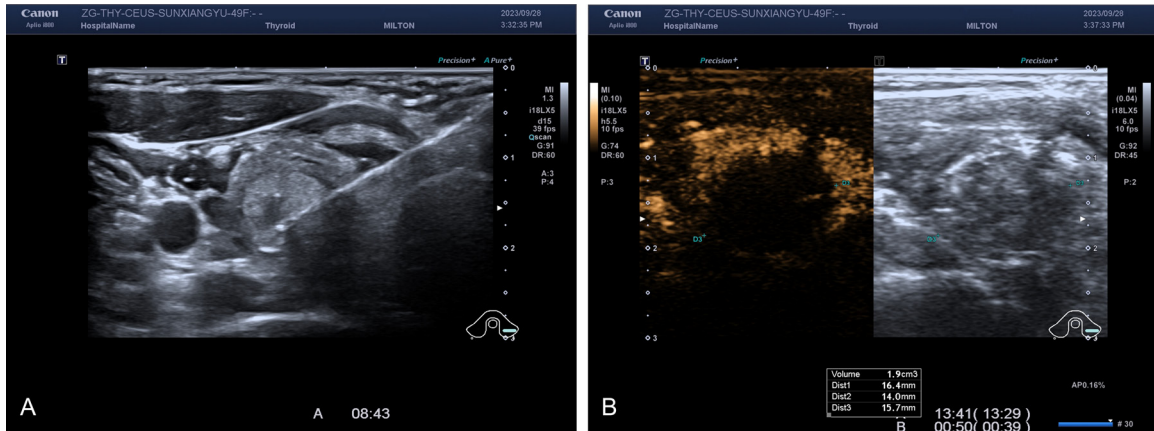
Ultrasound images during and after ablation of the two groups. A: Common ultrasound images of the thyroid during ablation; B: Immediate ablative thyroid CEUS. Note: CEUS: Contrast-enhanced ultrasound.
